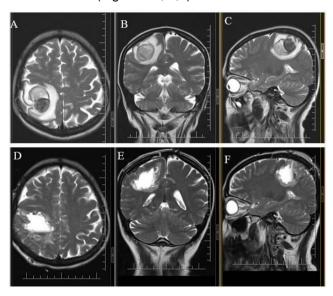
a, b, c: T2-weighted MRI; the lesion measured  $34 \times 39 \times 36$  mm in 3 different sections. The lesion shows heterogeneous intensity surrounded by hyperintense edema, and it was located in the right frontoparietal lobe. In addition, it occupied the hand region of the right motor cortex; d, e, f: T2-weighted MRI shows no edema, but there is a hyperintense appearance in area from which the metastatic brain tumor was removed.
